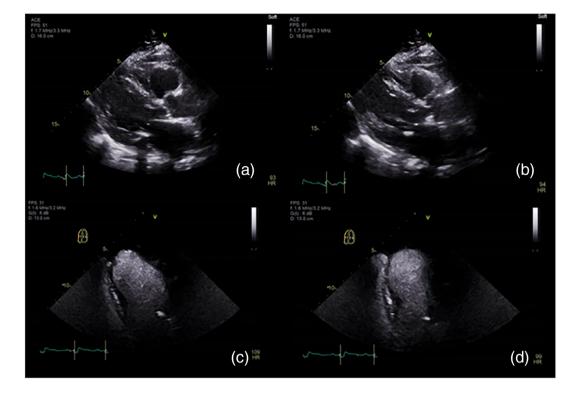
Representative parasternal long axis (a and b) and contrast enhanced apical four chamber (c and d) transthoracic echocardiography images taken at end diastole (a and c) and end systole (b and d) depicting wall motion abnormalities in the apex
